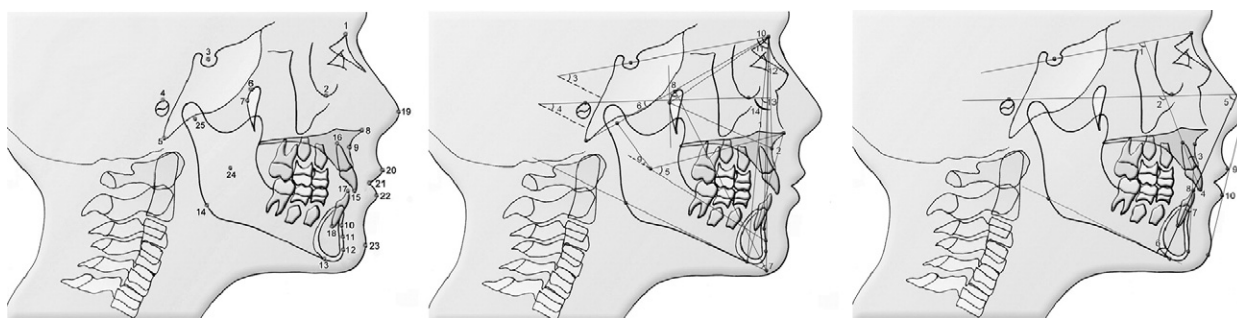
A, Hard- and soft-tissue landmarks used in lateral cephalometric radiographs: 1, nasion (Na); 2, orbitale (Or); 3, sella (S); 4, porion (Po); 5, basion (Ba); 6, pterygoid (Pt); 7, pterygoid vertical (Ptv); 8, anterior nasal spine (ANS); 9, A-point (A); 10, B-point (B); 11, Pm point (Pm) [suprapogonion]; 12, pogonion (Pog); 13, menton (Me); 14, gonion (Go); 15, maxillary incisor incisal point (Ui); 16, maxillary incisor root apex point (Ua); 17, mandibular incisor incisal point (Li); 18, mandibular incisor root apex point (La); 19, prosthion (Prn); 20, upper lip (UL); 21, embrasure point; 22, lower lip (LL); 23, soft-tissue pogonion (Pog'); 24, Xi point (Xi); 25, DC point (DC). B, Skeletal angular and linear measurements of lateral cephalograms: 1, nasion-menton distance (Na-Me); 2, ANS-menton distance (ANS-Me); 3, GoGnSN angle (GoGnSN); 4, FMA angle (FMA); 5, lower facial height angle (ANS-Xi-Pm); 6, cranial deflection angle (CD); 7, facial taper angle (FT); 8, facial axis angle (FA); 9, mandibular arch angle (MA); 10, SNA angle (SNA); 11, SNB angle (SNB); 12, ANB angle (ANB); 13, facial depth angle (FD); 14, maxillary depth angle (MD). C, Dental angular and linear measurements and soft-tissue measurements of lateral cephalograms: 1, maxillary central incisor to SN plane angle (U1-SN); 2, maxillary central incisor to FH plane angle (U1-FH); 3, maxillary central incisor to APog line angle (U1-APog); 4, maxillary central incisor to APog line distance (U1-APog); 5, FMIA angle; 6, IMPA angle; 7, mandibular central incisor to APog line angle (L1-APog); 8, mandibular central incisor to APog line distance (L1-APog); 9, upper lip to esthetic plane (UL-E); 10, lower lip to esthetic plane (LL-E).
